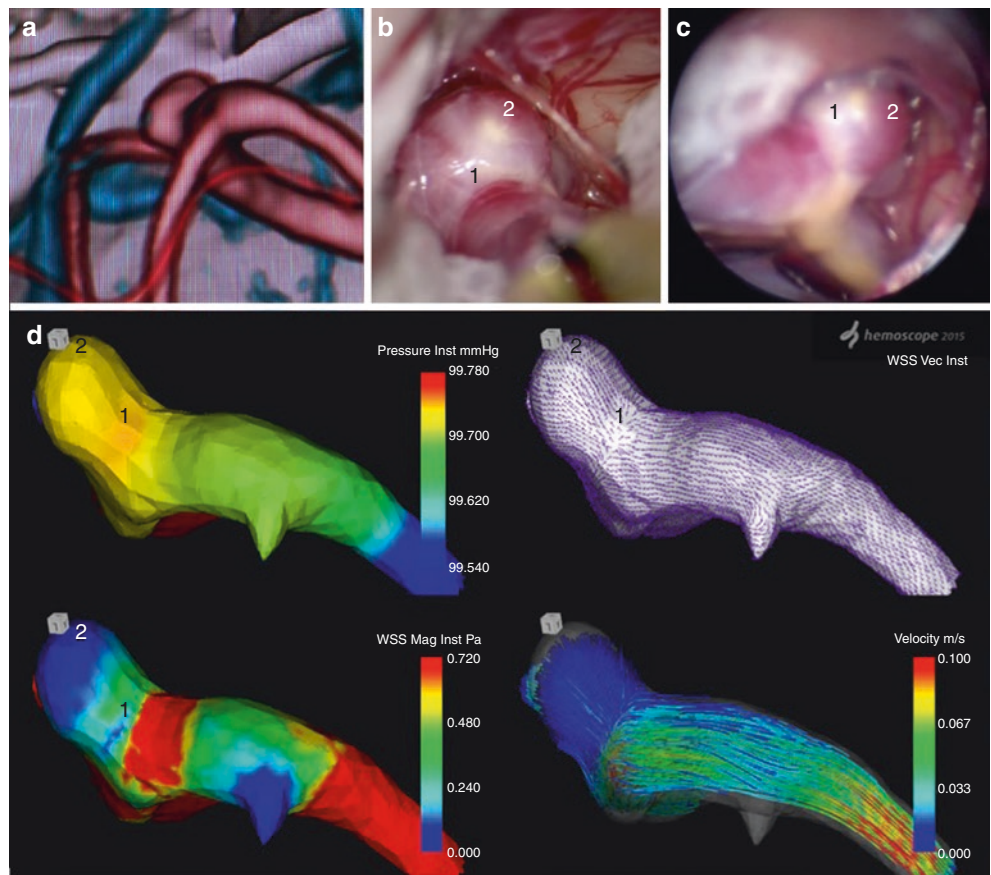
Patient n.14. (a) 3D CT-scan reconstruction of the left MCA aneurysm. (b) Intraoperative direct visualization revealed a TW bleb (1), in contrast with a normal wall dome (2). (c) CFD analysis showed the TW bleb to have high  $P$ , low WSS, divergent WSS vectors, and SL hitting the bleb wall with high velocity
